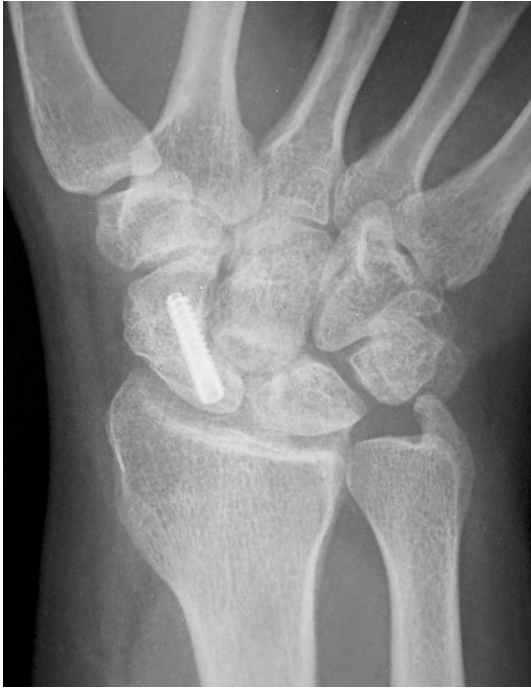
Anteroposterior radiograph of the right wrist at 24-month follow-up.
